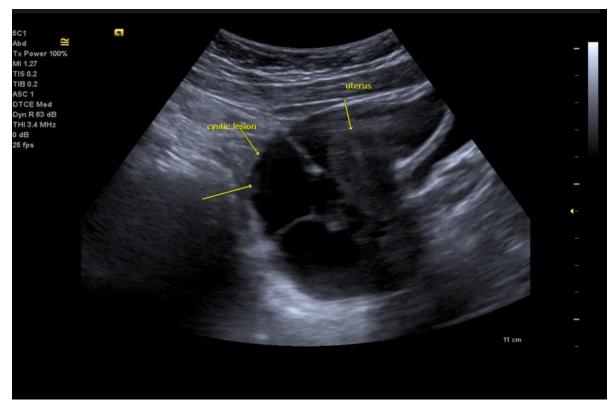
Ultrasonography showing a multinodular abnormality of 10.57×5.48 cm in diameter
